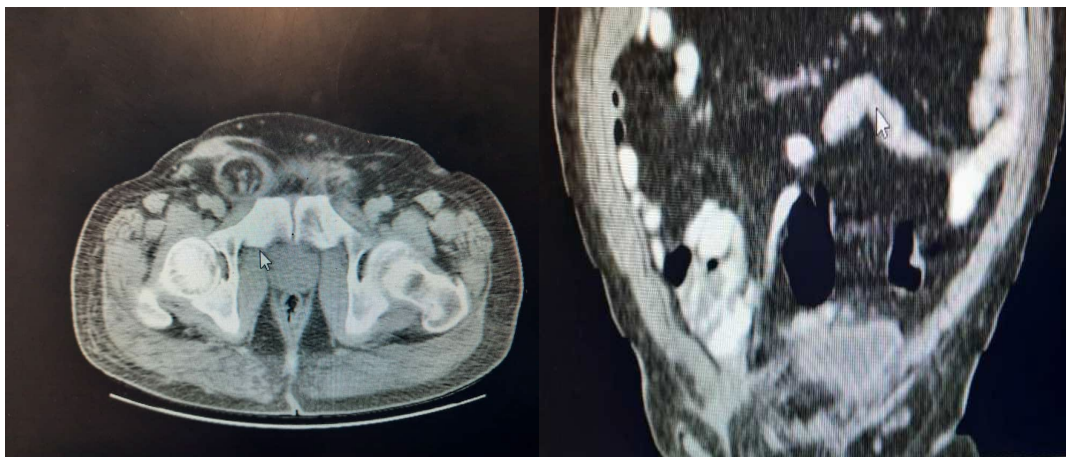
Abdominopelvic CT scan with IV and oral contrast with evidence of enterocutaneous fistula between the cecum and right inguinal region
